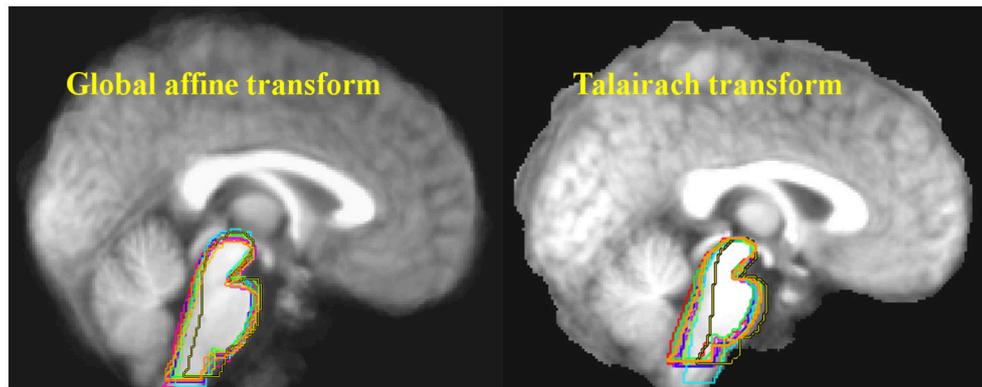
Ten structural MRI scans were aligned using two different standard neocortex-based spatial registration techniques. The brainstem of each individual brain was then traced to demonstrate how poorly they are aligned by these methods. In functional neuroimaging, detection of activation in a given brain structure is completely dependent upon the alignment of that structure across all subjects. No signal will be detected if the region of interest is not aligned. Reprinted from Napadow et al. (29) with permission from Elsevier.
